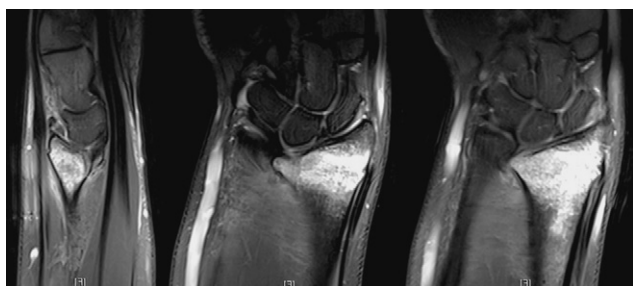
T2 weighted magnetic resonance imaging of the wrist demonstrating old changes at the ulnar-volar aspect of the distal radius (without associated high signal) and a cortical breach of radial styloid with an associated focus of high signal consistent with a new fracture.
